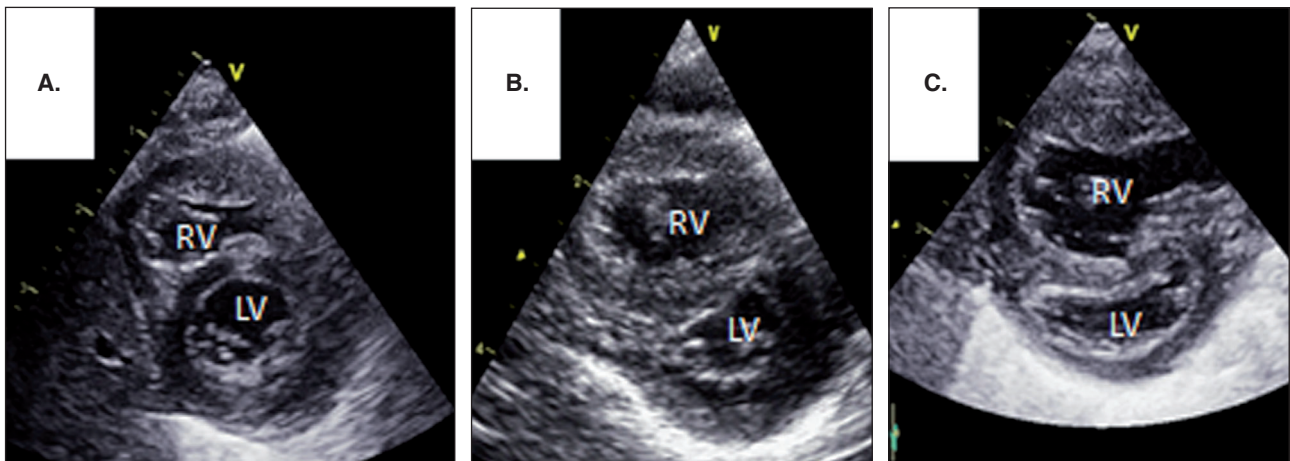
Short axis parasternal view at the level of mitral valve. A. Normal curvature of IVS and normal size of RV. B. Flat IVS with mild dilatation of RV due to pulmonary hypertension. C. IVS bows to the LV with significant dilation of RV due to severe supra-systemic pulmonary hypertension.
